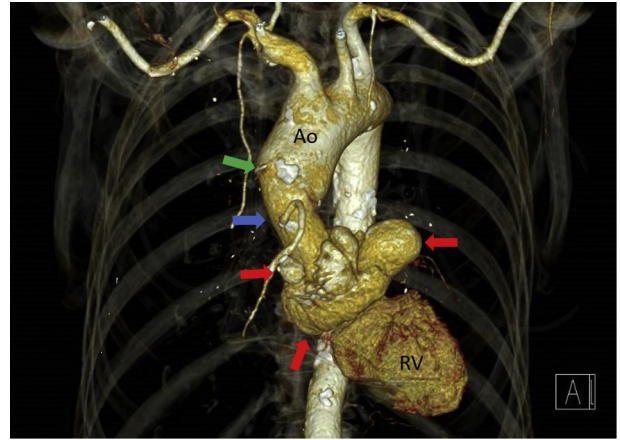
A three-dimensional reconstruction from CTA, viewed anteriorly, showing the extent of the pseudoaneurysm (red arrows), the prosthetic aortic root and proximal ascending aorta (blue arrows), and the anastomosis with the native aorta (green arrow). Ao, Aorta; RV, right ventricle.
